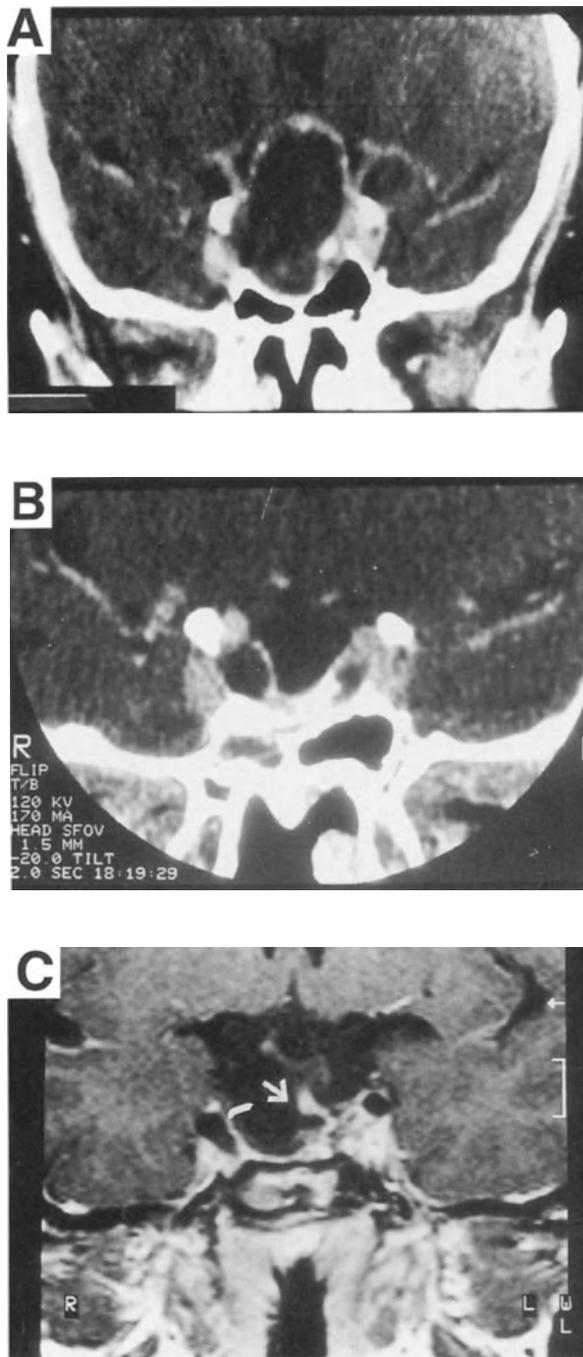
CT coronal views of a cystic craniopharyngioma before (A) and shortly after surgery (B). (C) MRI coronal view, 5 yr after surgery showing no tumor remnants and stalk displacement (arrow).
